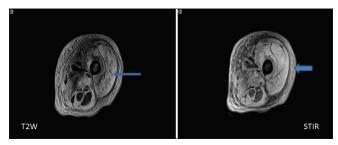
T2-weighted and STIR axial images of left thigh show diffuse swelling and hyperintensity of vastus muscles more in vastus lateralis muscle and there is loss of intermuscular septae (arrow)
